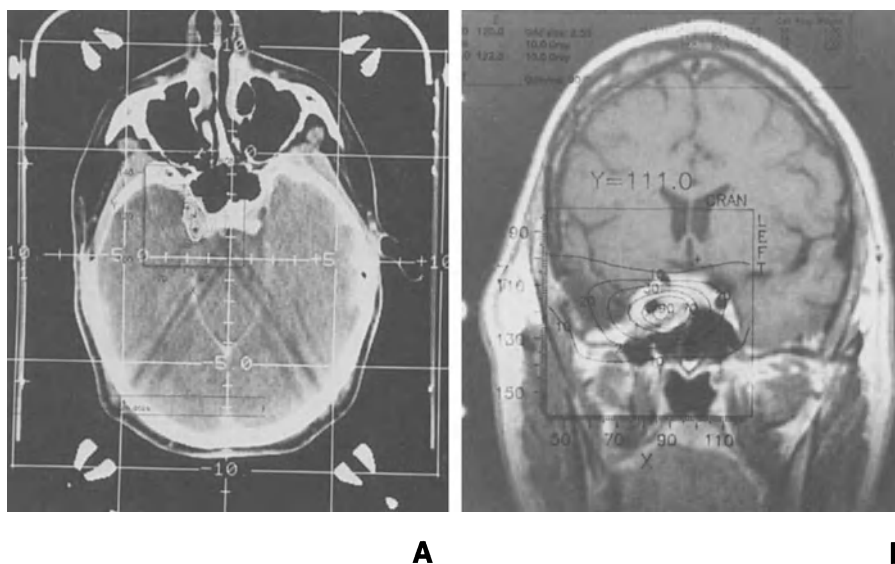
(A) Stereotactic coronal MRI of residual meningioma in the left cavernous sinus. Status after microsurgery. The isodose configuration is superimposed on the MRI image. (B) Stereotactic transaxial CT scan of residual meningioma involving the left cavernous sinus. Status after microsurgery. The isodose configuration for the given slice is superimposed on the CT film
